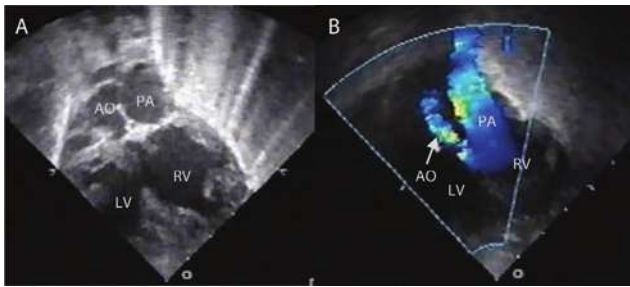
Subcostal 4-chamber views in case no. 2 : A. double outlet right ventricle, the aortic valve is small with sub-valvular and valvular aortic stenosis, PA hypoplastic ascending aorta positioned on the right side of pulmonary trunk. B. with color Doppler the flow could be visualized. *LA – left atrium, LV– left ventricle, RV – right ventricle, PA – pulmonary artery, AO- aorta.*
